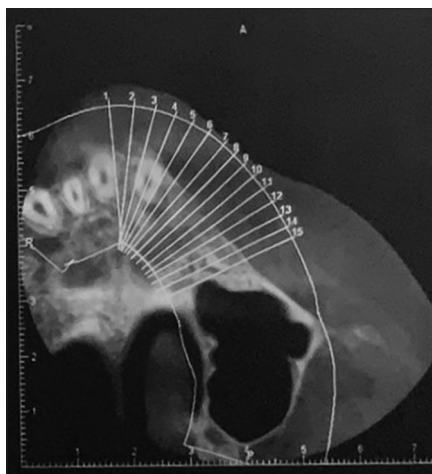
Cone-beam computed tomographic image of the maxillary alveolar ridge 6 months after surgery.
